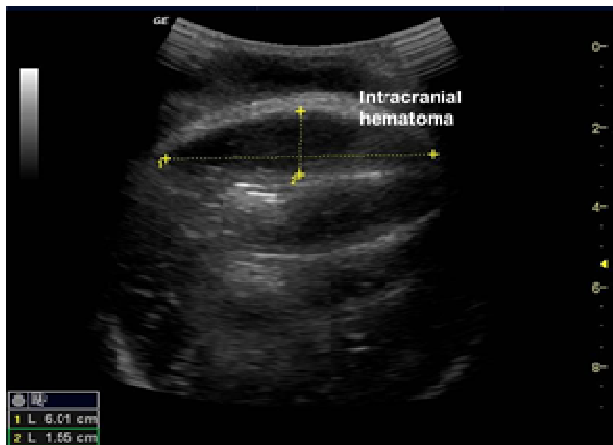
Image of ultrasound using 3, 5 - 7 MHz convex probe. The intracranial hematoma is fully displayed, measuring $6.0 \times 1.5 \times 4.9$ cm.
